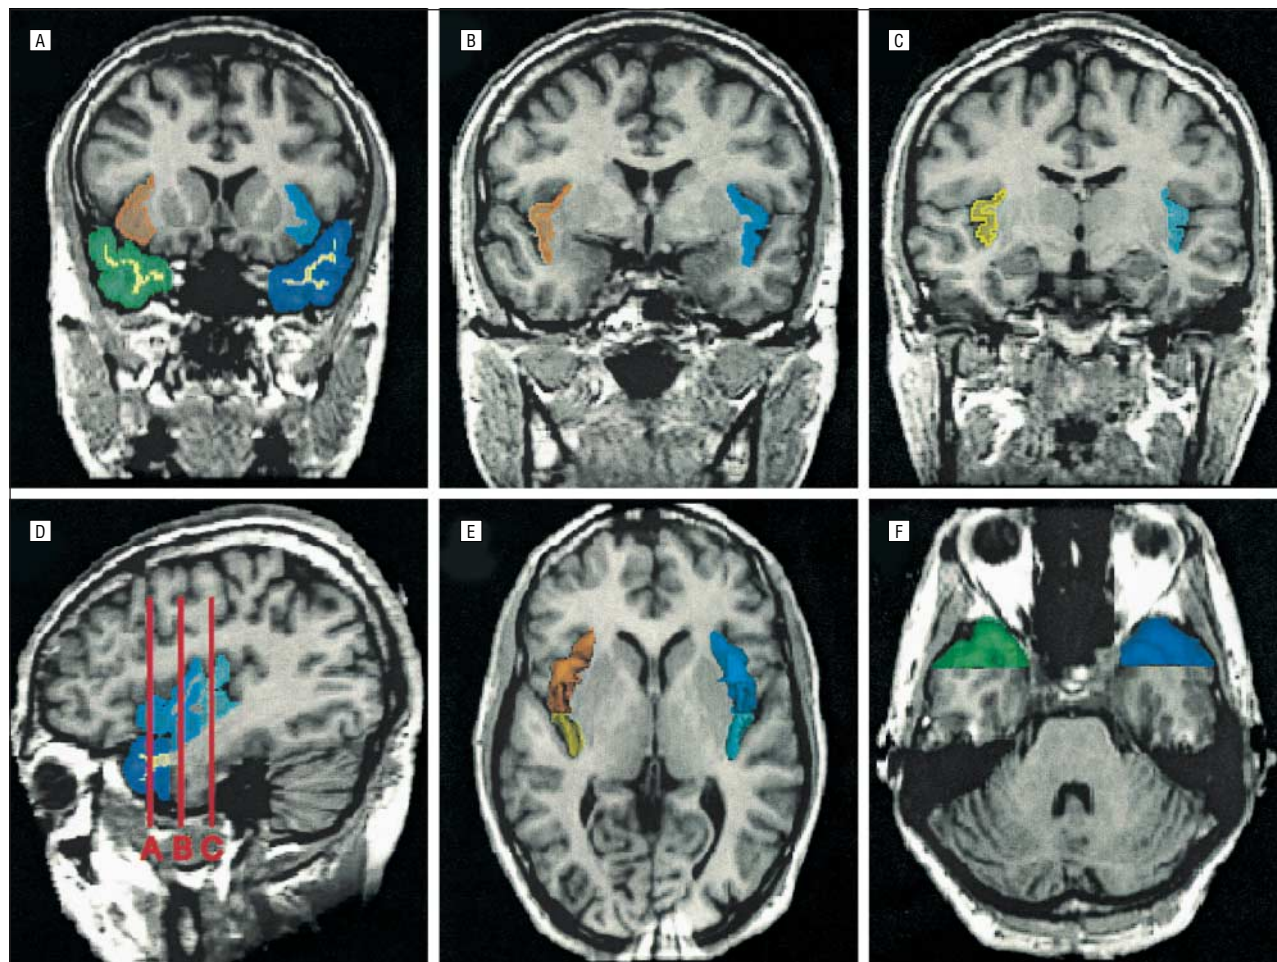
Two- and 3-dimensional images of paralimbic regions of interest based on magnetic resonance imaging data from a control subject. The gray matter of the anterior insular cortex is colored blue on subject left and orange on subject right. The gray matter of the posterior insular cortex is colored light blue on subject left and yellow on subject right. The white matter of the bilateral temporal pole is colored ivory. The gray matter of the temporal pole is colored purple on subject left and green on subject right. A, B, and C, Delineation of the paralimbic regions of interest on coronal slices: A shows the rostral part of the anterior insular cortex adjacent to the orbital cortex and the temporal pole; B, the caudal portion of the anterior insular cortex; and C, the middle portion of the posterior insular cortex. D, Sagittal view of the insular cortex and the temporal pole in the left hemisphere. The coronal lines A, B, and C correspond to the planes of panels A, B, and C, respectively. E and F, Three-dimensional reconstruction of insular cortex (E) and temporal pole (F) gray matter superimposed on the axial plane.
